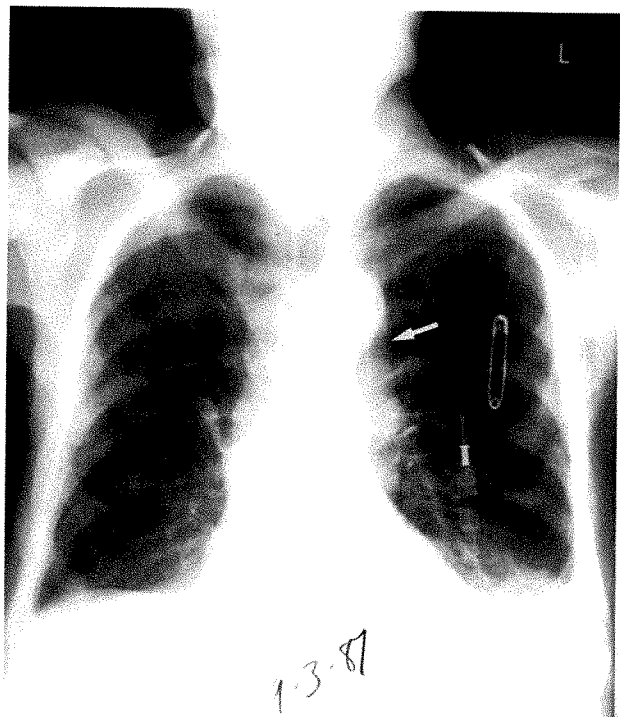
Chest x-ray (PA view) with arrow pointing to the catheter tip. Note the paravertebral location of the catheter tip at the level of the T3 vertebral body.
